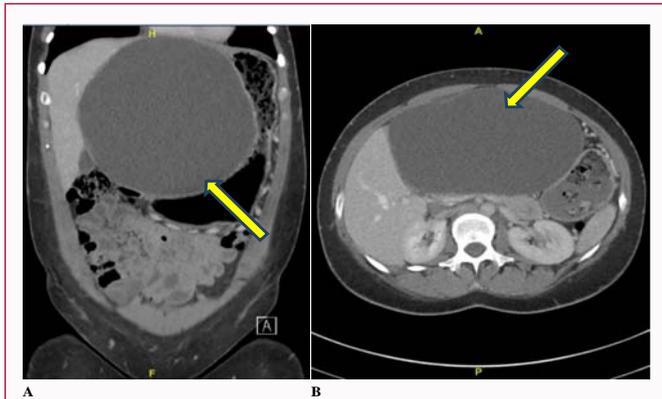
Coronal (A) and Sagittal (B) CT on most recent admission showing hepatic mass (see arrows) measuring 19.5 cm x 18.3 cm x 11.9 cm. Note interpositions between liver, stomach, and pancreas.
